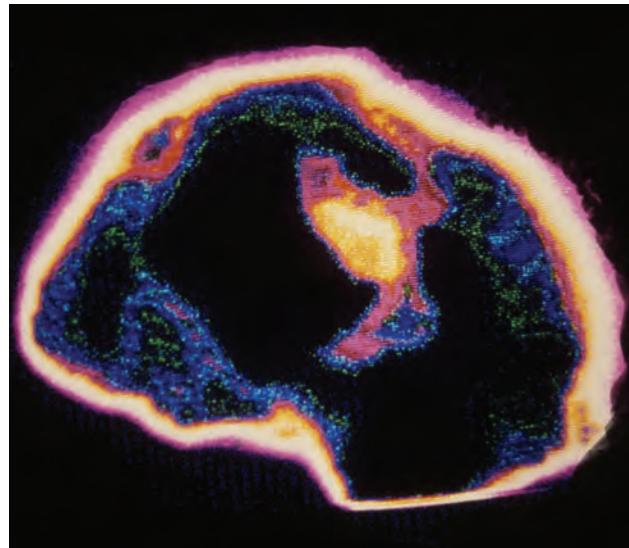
A SPECT image of the brain of an alcoholic. The non-coloured areas indicate decreased brain activity. (This is a raw SPECT image that would be combined with other similar images to form a 3-D image of the brain.)
